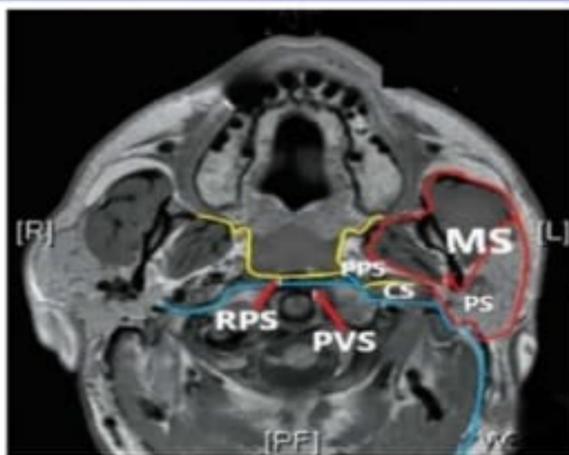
MRI Neck -axial section-at oropharynx level ; 3 layers of Deep cervical fascia (DCF)- Red-superficial ;Yellow-middle ;Blue-deep. MS-masticator space;PS-Parotid space;PMS-Pharyngeal mucosa space; CS- Carotid space; PPS-Parapharyngeal space; RPS- Retropharyngeal space; DS-Danger space; PVS-Prevertebral space.
